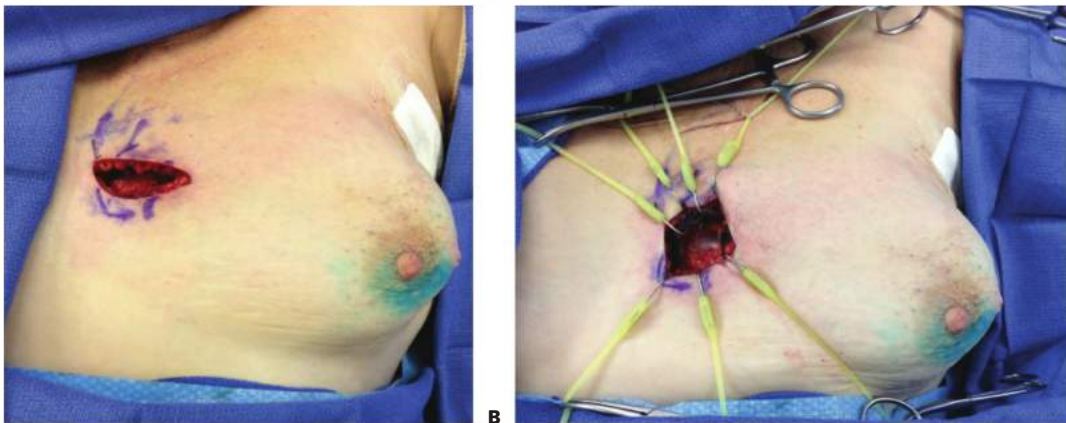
• A. Parasternal incision in conserved breast with exposure of pectoralis muscle. B. Lone Star hook retractors placed to retract skin to expose muscle.
